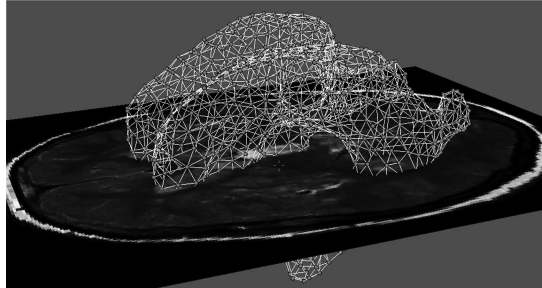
Mesh model of a brain ventricle, projected on a PD MRI image.
